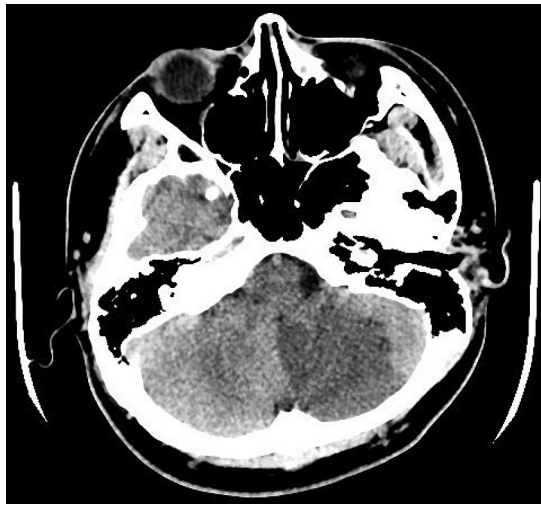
Plain CT brain, showing left cerebellar infarction.
